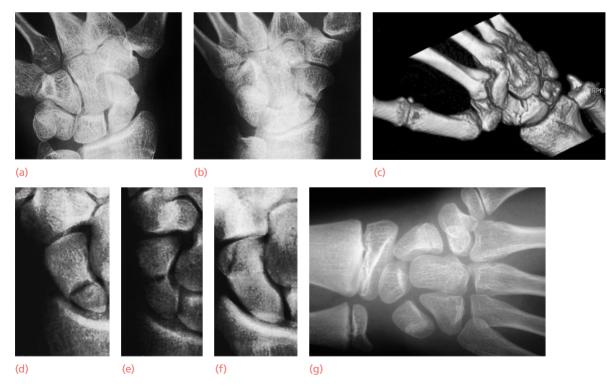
Fractures of the scaphoid – diagnosis (a) The initial AP view often fails to show the fracture; (b) always ask for a 'scaphoid series', including two oblique views. If the clinical features are suggestive of a fracture, immobilize the wrist and repeat the X-ray 2 weeks later when the fracture is more likely to be apparent. (c) A CT scan is useful for showing the fracture configuration. The fracture may be through (d) the proximal pole, (e) the waist, or (f) the scaphoid tubercle. Occasionally these fractures are seen in children (g).
